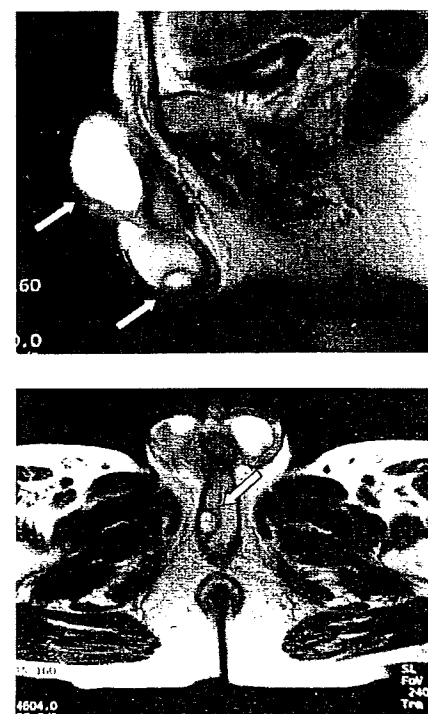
T2-weighted MRI findings before admission (July 2004). Arrows indicate multiple high-intensity areas in the periurethra and testes.
